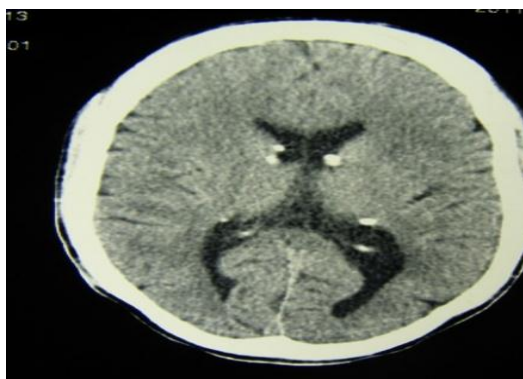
CT – head (tuberous calcification).
